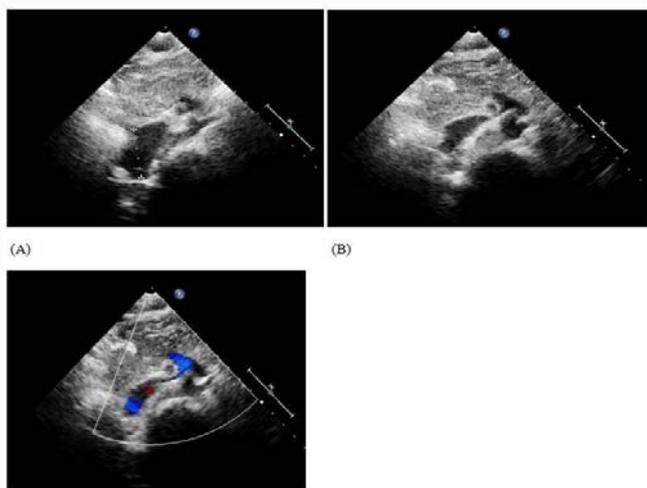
A: The inferior vena cava widened markedly; B: Part of the portal vein drains into the inferior vena cava and part of it runs to the liver; C: Color Doppler imaging showed that part of venous blood flowed into the inferior vena cava, part of it went to the liver, and the blood flow into the liver was retrograde.
